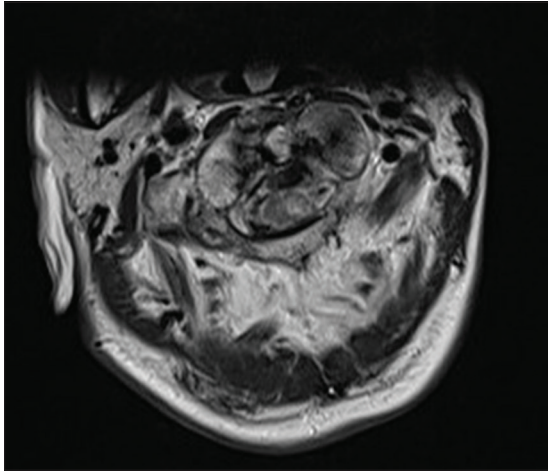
Preoperative cervical axial magnetic resonance imaging demonstrating cord compression from the fracture pattern with myelomalacia.
